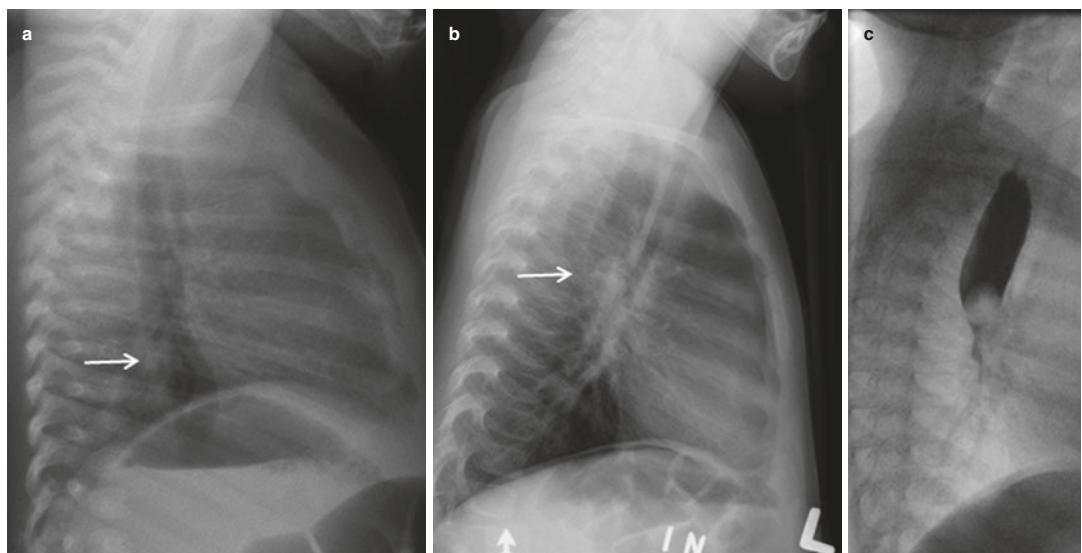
(a) Lateral chest radiograph of a 5-week-old girl, showing air throughout the distended esophagus (arrow), which is commonly seen in normal young pediatric patients. (b) Lateral view of a 19-month-old girl who presented with a 4-day history of vomiting and fever. The
